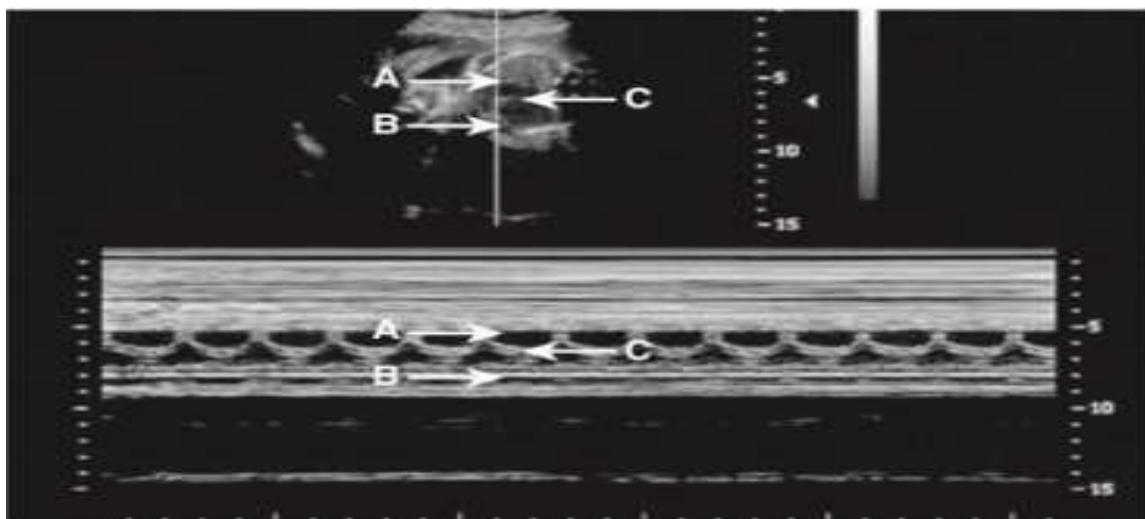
12-3 M-Mode screen. M-mode ultrasound displays changes in echo amplitude and position over time. Viewing changes in echo position is useful in evaluating fast-moving structures such as heart valves and chamber walls. Here, the three major moving structures in the upper gray scale image of the fetus are recorded in the corresponding M-mode image and include the proximal
